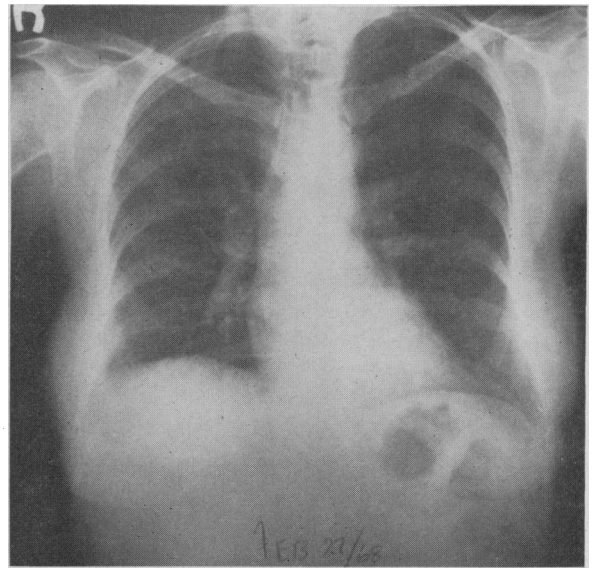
Case 3. Radiograph showing considerable clearing but some residual increased lung markings most marked at the bases.
